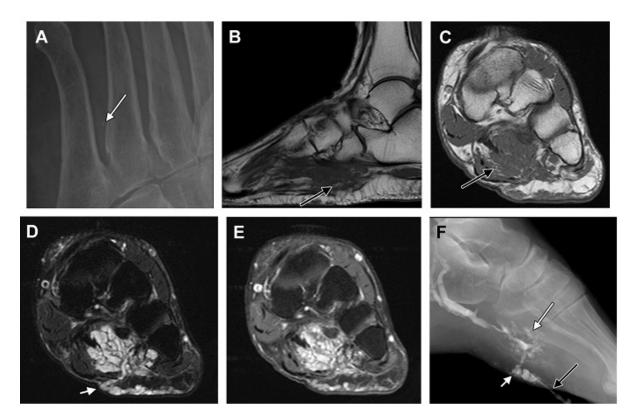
Venous malformation in the foot of a 49-year-old woman with a left foot mass since childhood, now enlarging and painful; Figure A - Oblique radiograph shows mild demineralization of the bones and a small phlebolith (arrow). Figure B - Sagittal T1-WI shows atrophy of the plantar muscles with increased intramuscular fat (arrow). Figure C - Short-axis T1-WI shows atrophy of the plantar muscles dintramuscular fat (arrow). Figure D - Short-axis T2-WI with FS shows a large vein (arrow) draining into the lobulated, septated lesion. The lesion does not respect tissue planes and extends along the fascia, between tendons, and within muscle. Figure E - Short-axis delayed post-contrast T1-WI with FS shows pooling of contrast within the lobulated, septated mass. Figure F - Venogram obtained before sclerotherapy shows the injection needle (black arrow) in the vein indicated in panel.
